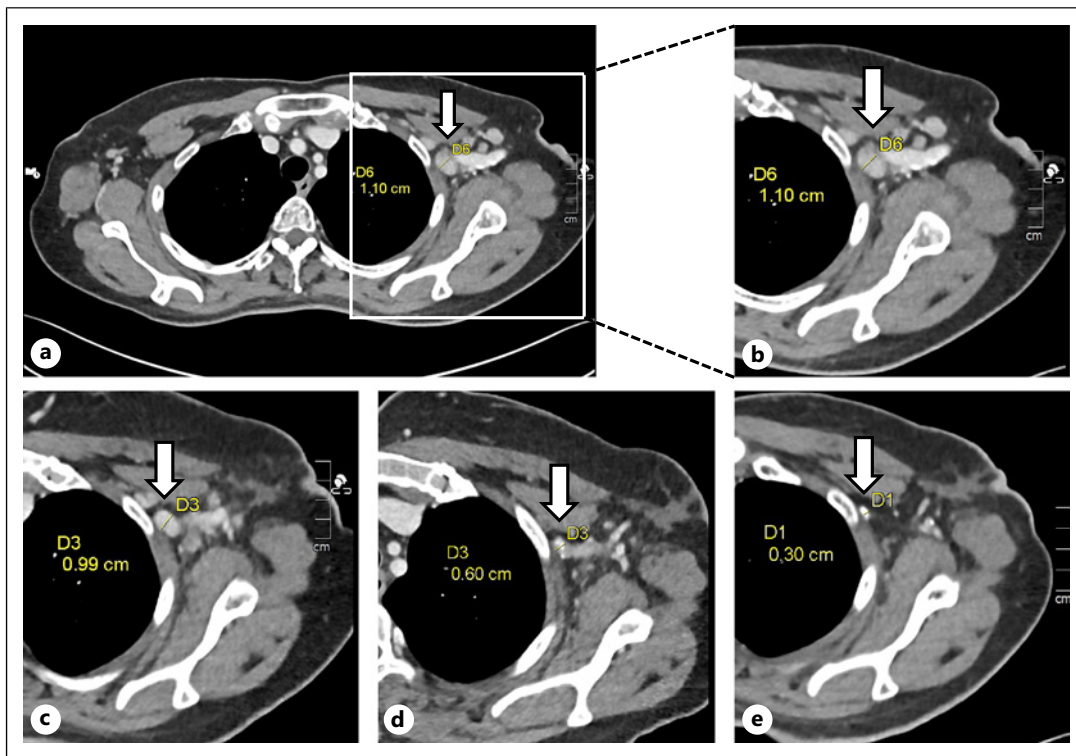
Computed tomography (CT) scans of an axillary lymph node metastasis in the course of treatment. a CT scan at the initial diagnosis. b Zoomed section from a. c CT scan after treatment with doxorubicin and cyclophosphamide, the first half of chemotherapy, showing partial remission. d CT scan after treatment with docetaxel, the second half of chemotherapy, showing continued remission. e CT scan after radiotherapy showing complete remission.
